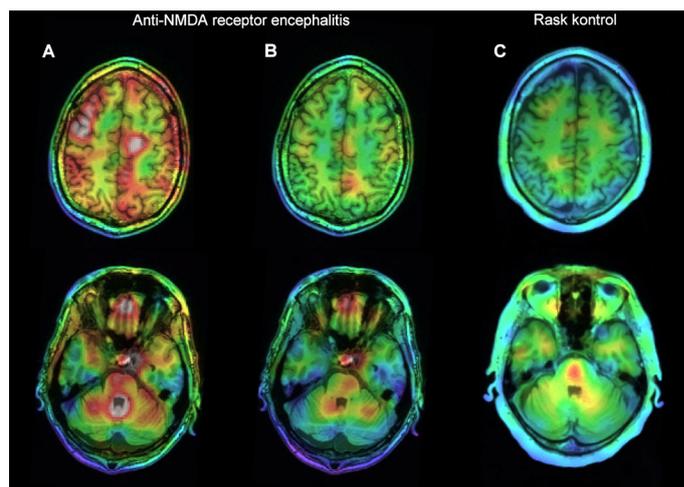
$[^{123}\text{I}]\text{CLINDE}$  SPECT and coregistered MRI in a patient with anti-NMDAR encephalitis. (A) At the start of immunotherapy  $[^{123}\text{I}]\text{CLINDE}$ -binding to TSPO was strongly increased in cortical and subcortical brain regions but almost normalized (B) after seven weeks of immunotherapy compared to (C) a healthy volunteer. The patient is a 35-year-old man who presented with psychiatric symptoms dominated by perceptual difficulties and delusions that resemble symptoms following intoxication with NMDA antagonists. Anti-NMDA-receptor antibodies were detected in CSF. Cerebral MRI was unremarkable. After seven weeks of immunotherapy the patient was back at work part-time as a computer scientist despite mild cognitive problems. The image appeared as the front cover of Neurology in February 2015. Figure from [25], Copyright © 2015 American Academy of Neurology.
